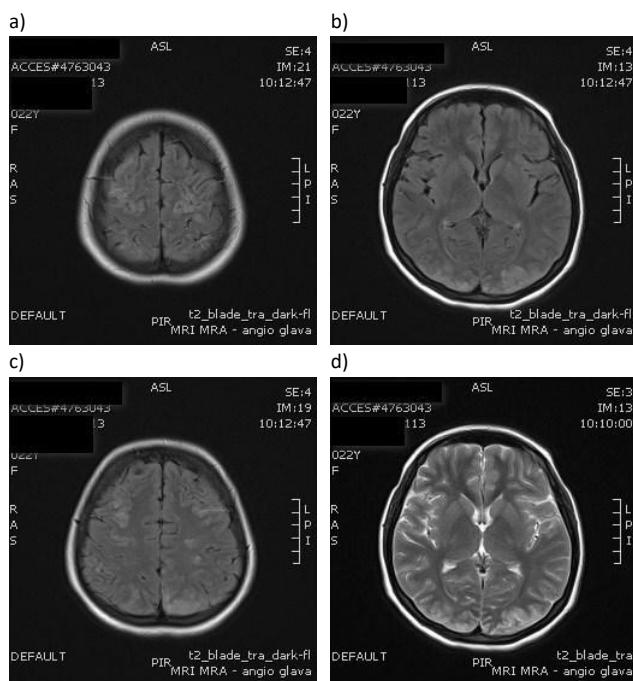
MRI of the cranium
